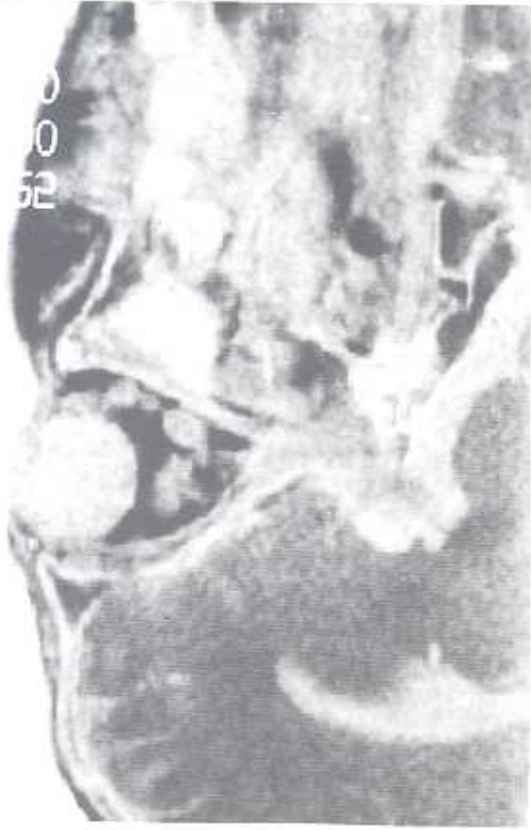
Orbital MRI of the patient showing optic gliomas.
